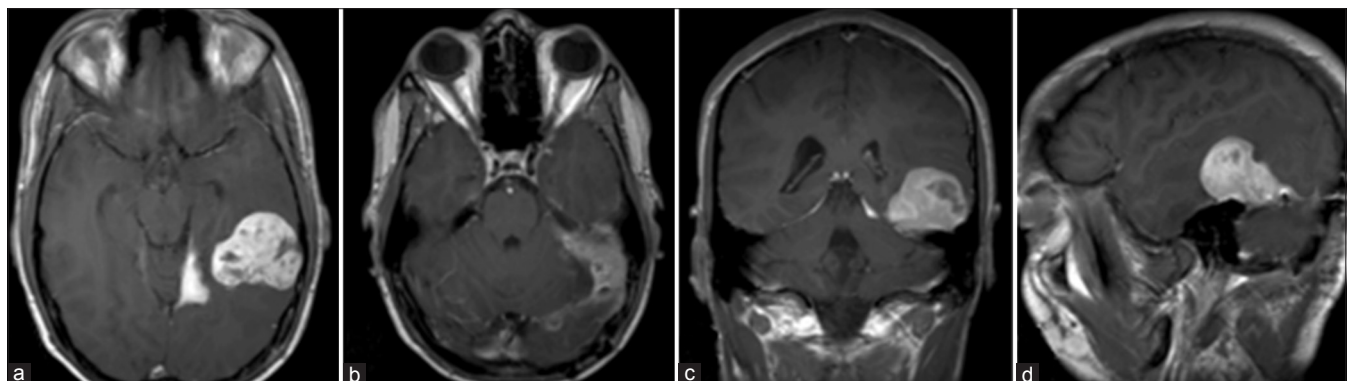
Axial (a and b), coronal (c) and sagittal (d) postgadolinium T1-weighted MRI studies showing tumor progression 2-months following surgery
